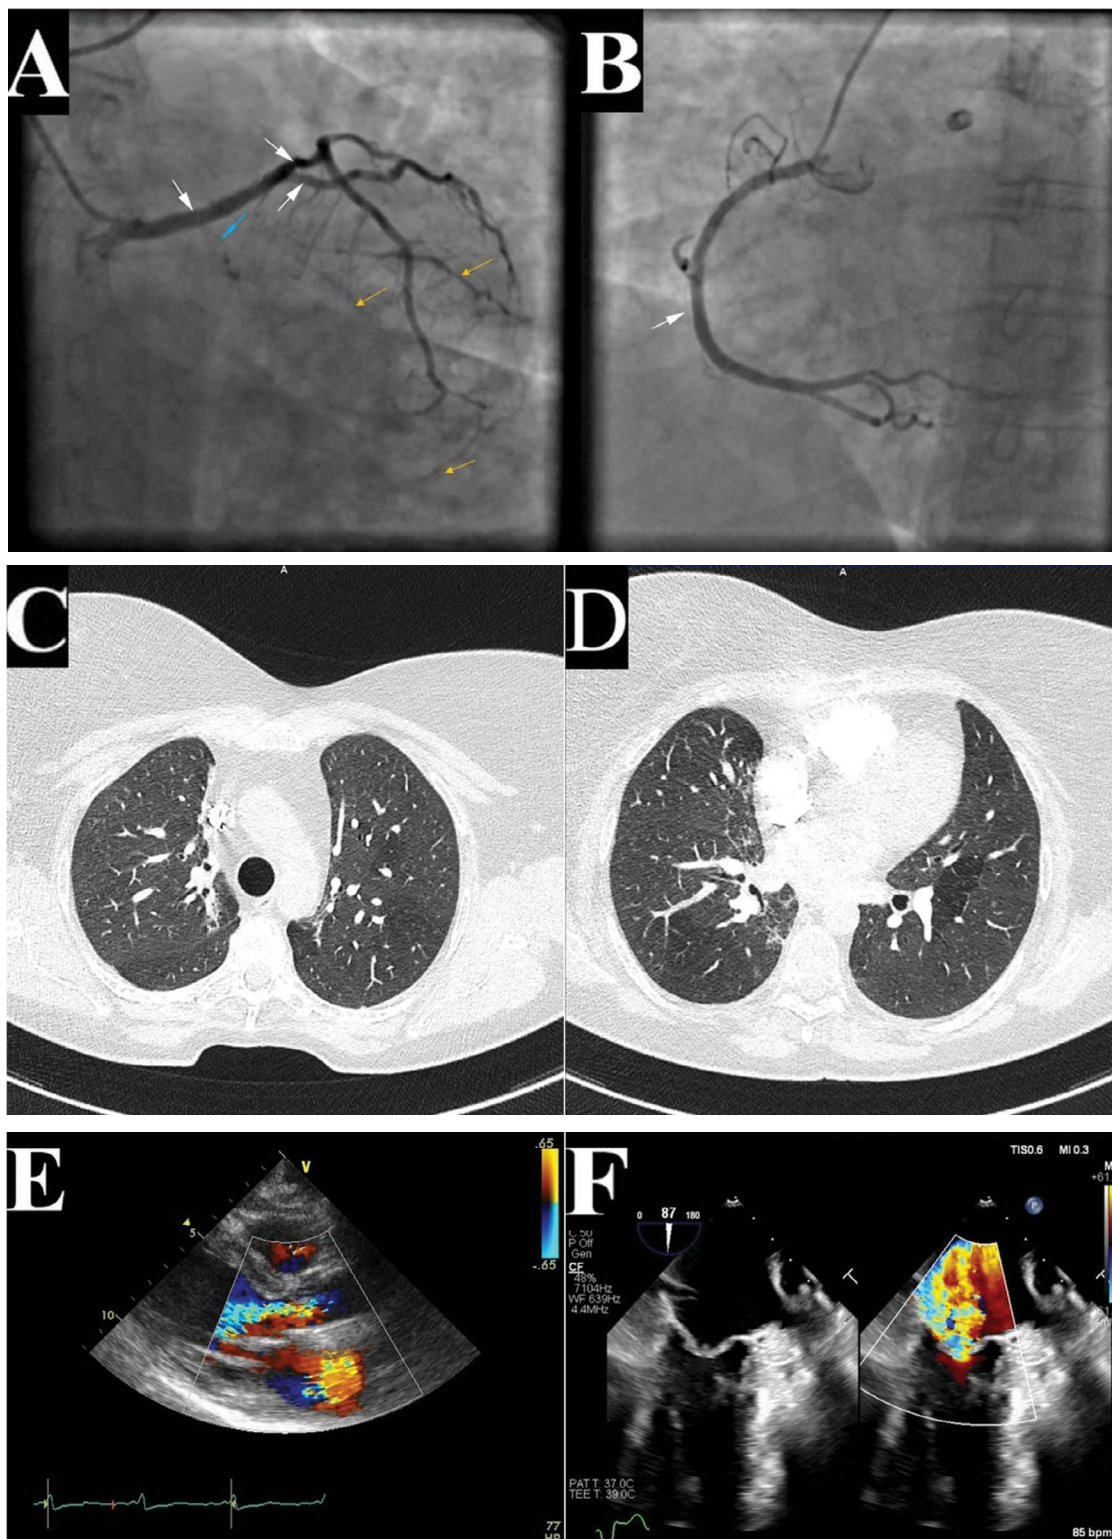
Hodgkin lymphoma’s treatment complications: A. Coronary angiogram showing good long-term patency of the stents implanted in left main coronary/left anterior descending and diagonal branch (indicated with white arrows). Chronic total occlusion of the proximal circumflex branch is indicated with a blue arrow – retrograde filling of the distal marginal branches can also be appreciated (indicated with yellow arrows); B. Coronary angiogram showing proper long-term effect with minimal restenosis in stent implanted in mid-right coronary artery (indicated with white arrow); C. Chest computed tomography imaging: pulmonary reconstruction 1 mm, bilaterally paramediastinal consolidation and fibrous changes of the lung parenchyma after radiotherapy, slightly pulling oblique interlobar fissures; D. Chest computed tomography imaging: pulmonary reconstruction 1 mm, paramediastinal consolidation and fibrous changes of the right lung’s parenchyma after radiotherapy; E. Transthoracic echocardiogram in the parasternal long axis showing moderate aortic insufficiency; F. Severe insufficiency of the mitral valve visible in the mid-esophageal 2-chamber view of transesophageal echocardiogram
